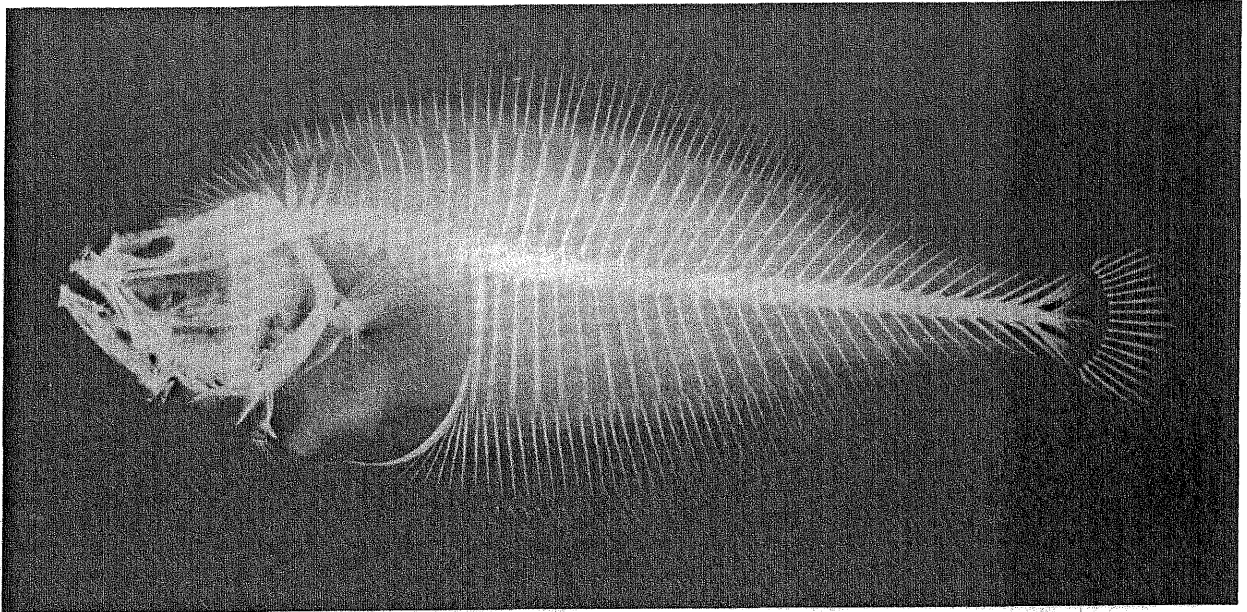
X-ray of normal (above) and "dwarf" (below) summer flounder, *Paralichthys dentatus*, showing fused vertebrae.
